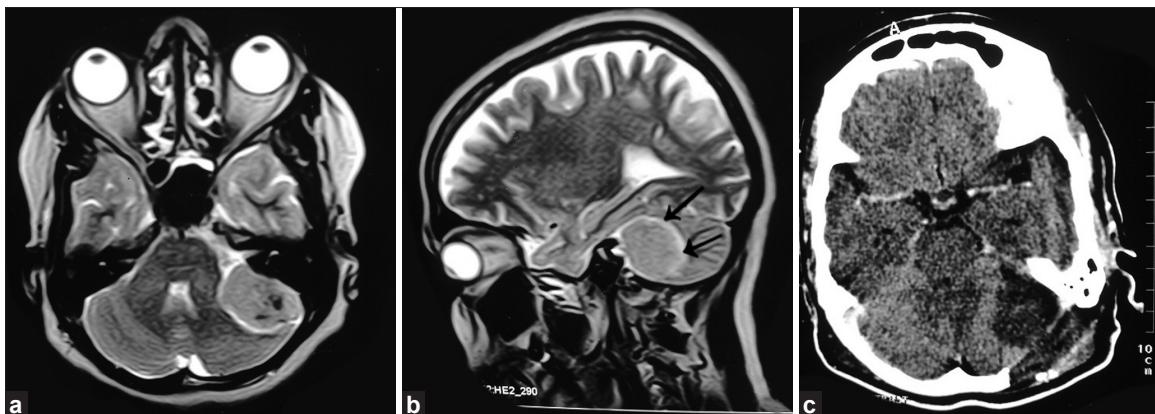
Left lateral petrous meningioma with postoperative CT scan s/o retromastoid craniectomy defect with gross total excision of lesion
